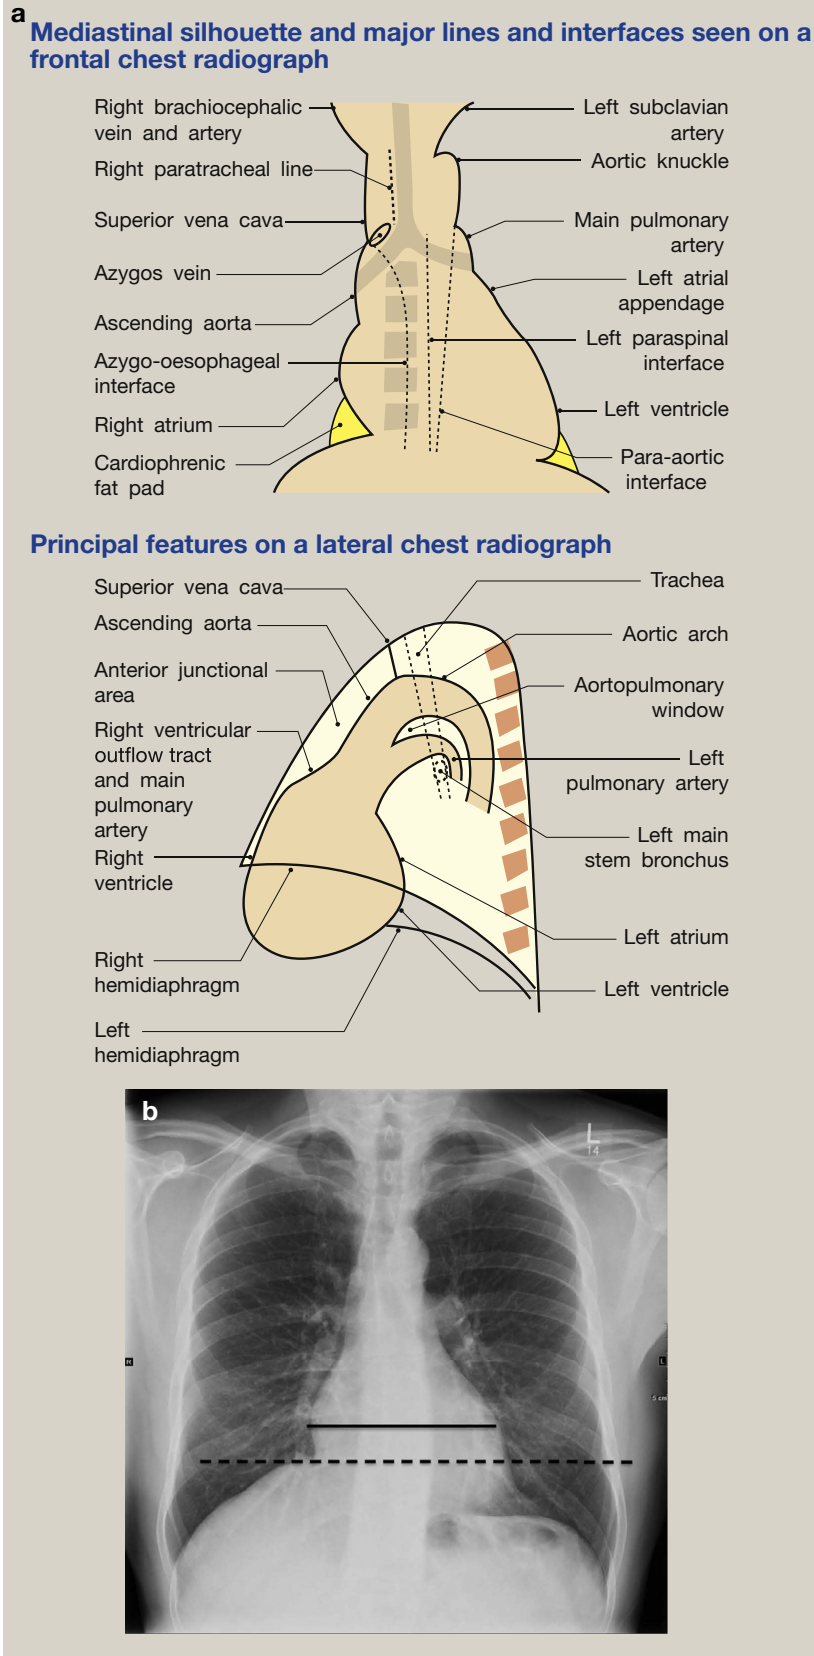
(a) Principal structures on frontal and lateral chest radiographs. (b) Example of normal chest radiography with measurement of cardiac size: the solid line depicts the maximum transverse diameter, the dotted line the thoracic width. The cardiothoracic ratio is the ratio of maximum transverse diameter to thoracic width.
